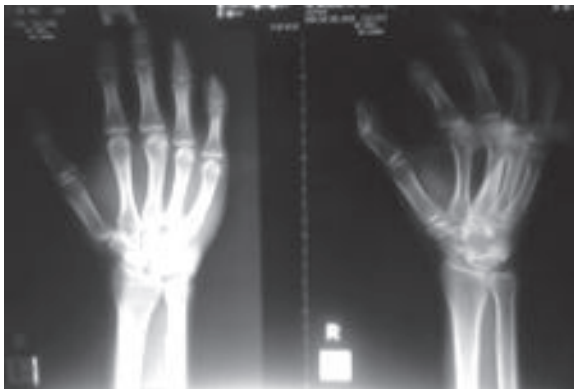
X-ray right hand
